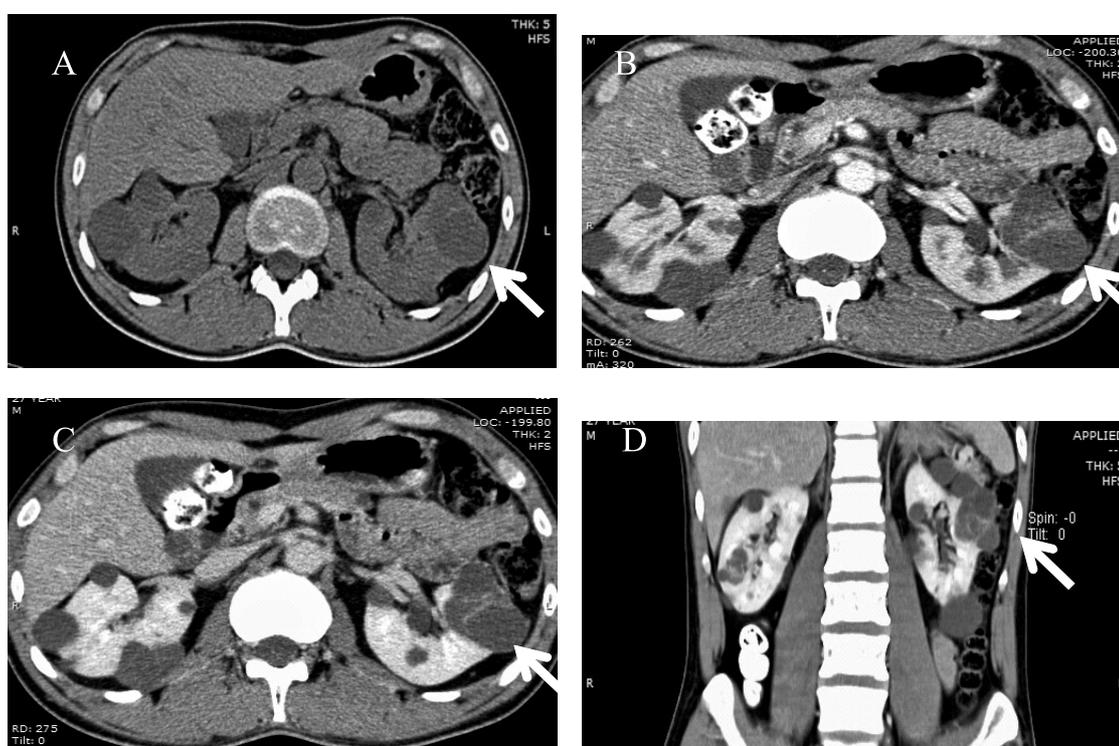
Images from a 27-year-old man with von Hippel–Lindau disease with multilocular cystic renal cell carcinoma. Axial and coronal precontrast (A), corticomedullary phase (B) and nephrogenic phase (C and D) images. A. Precontrast CT: A 2.5 cm × 3.0 cm multilocular cystic lesion at the midpole of the left kidney (arrow). B. Corticomedullary phase: enhancing thickened internal septa in the tumor. C. Nephrogenic phase: persist enhancement of thickened internal septa. D. The coronal image on nephrogenic phase: thickened enhance internal septa with multilocularity appearance of this tumor. He also had multiple simple renal cortical cysts in both kidneys, another multilocular cystic RCC in right kidney (arrowhead in D).
